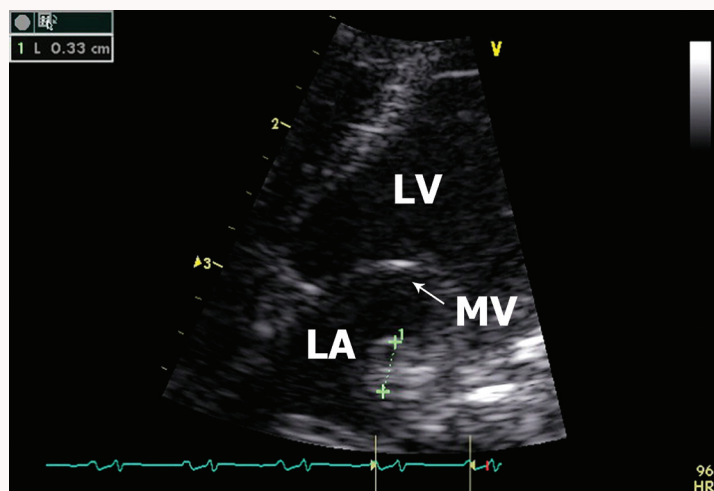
Post-procedural echocardiogram showing a echodense “RFCA-lesion” of the left atrium (LA) of 2 x 3 mm. just above the posterolateral part of the mitral ring. (LV = left ventricle, MV = mitral valve).
